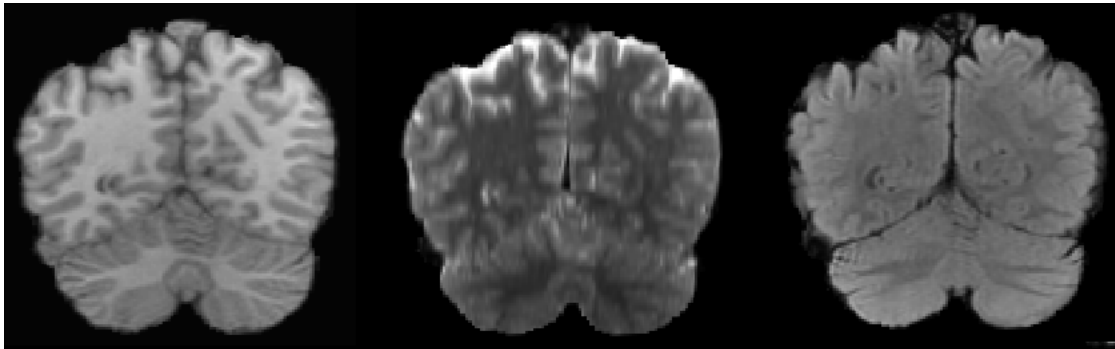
Different MRI contrasts: T1 (left), T2 (middle) and FLAIR (right).
